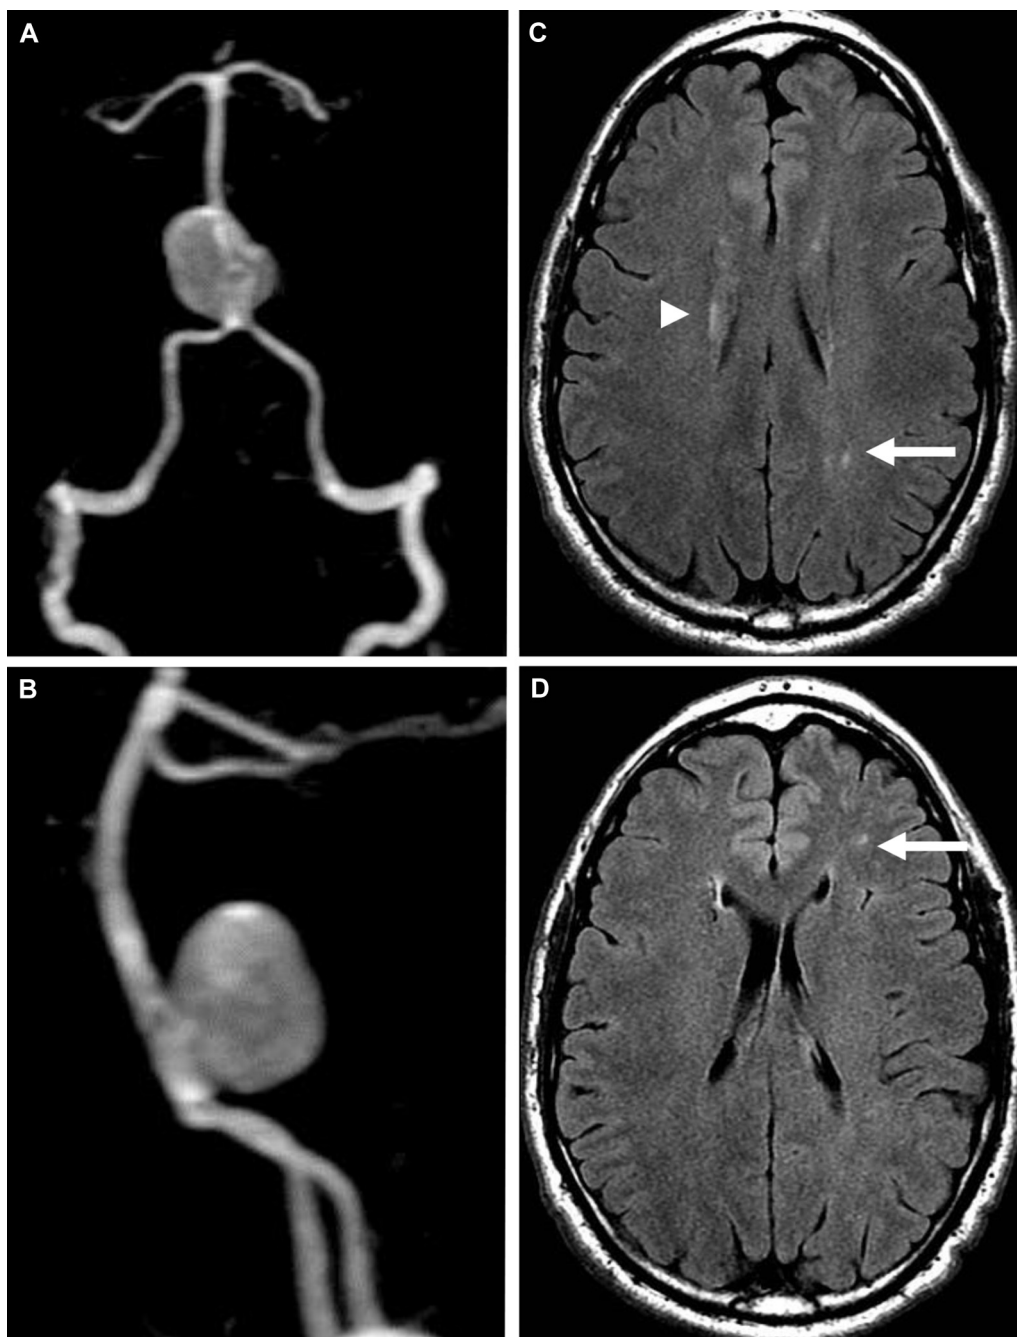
Brain magnetic resonance imaging (3-Tesla magnetic resonance imaging) findings. A and B, Three-dimensional reconstruction of contrast-enhanced magnetic resonance angiographic data, revealing a 19.5 × 17-mm saccular aneurysm of the basilar artery. C and D, Axial fluid-attenuated inversion recovery images demonstrating the presence of white matter hyperintensities (*arrow*) and linear periventricular hyperintensities (*arrowhead*).
